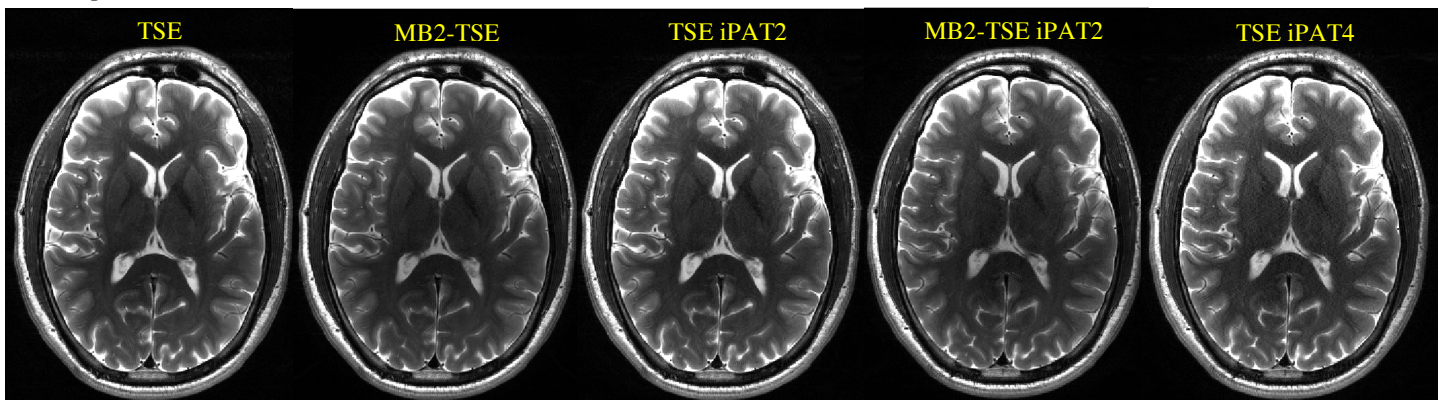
Representative traditional TSE and MB-TSE T2-weighted images of the brain. Even with shorter TR and acquisition time, the MB-TSE images have very similar T2-weighted contrast as the traditional TSE images, except for the cerebrospinal fluid region.
